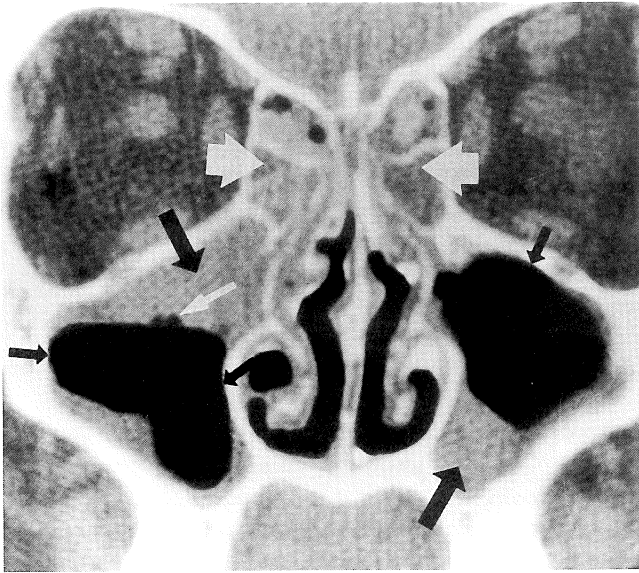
A CT scan of the sinuses of an adult with a common cold of 4 days' duration. Abnormalities of the roof and floor of the maxillary sinuses (*large black arrows*) are evident. Gaseous bubbles in the material (*small white arrow*) and its irregular distribution along the walls of the sinus cavity suggest that it is thick exudate adherent to the sinus wall rather than mucosal swelling. Portions of the air-bone interfaces of the sinus wall are normal (*small black arrows*). The uneven distribution of the abnormalities is not compatible with mucosal swelling, which would be expected to be more uniform. Bilateral disease of the ethmoid sinuses is also present (*large white arrows*).
